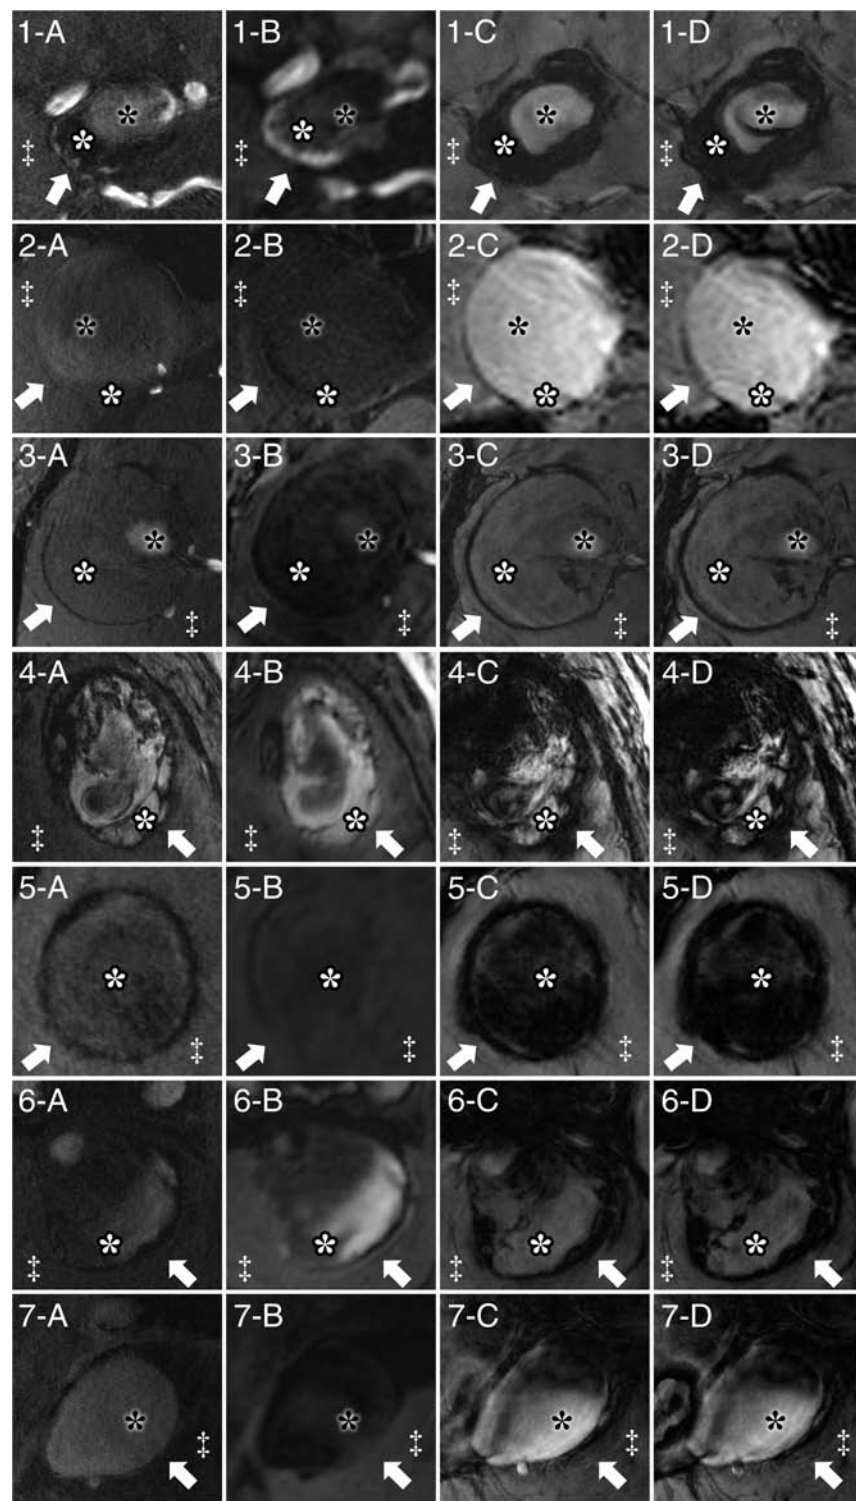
Delineation of giant intracranial aneurysms by 7T MR imaging for all 7 patients by TOF-MRA (A), MPRAGE (B), magnitude imaging (C), and SWI (D). Specific structures are marked identically in all subfigures. Arrows indicate the aneurysm wall; *white asterisks*, intraluminal thrombus; *black asterisks*, flow lumen; and *double daggers*, brain parenchyma. Aneurysm walls show hypointense signal in TOF-MRA, magnitude imaging, and SWI and heterogeneous signal intensity in MPRAGE.
